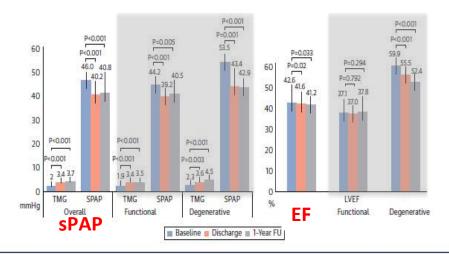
Echocardiographic Measurement of Transmitral Pressure Gradient, SPAP, and Ejection Fraction, at Baseline, Discharge, and 1-Year Follow-Up
